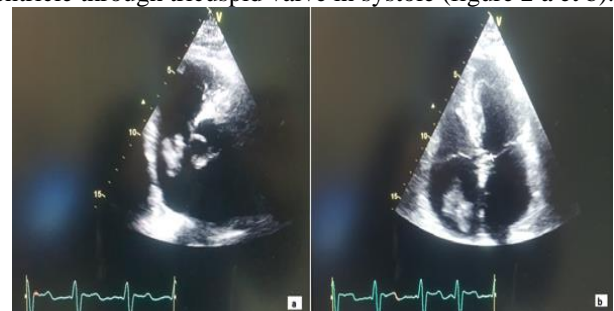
Transthoracic echocardiography: floating right atrial thrombus protruding towards the Right ventricle in systole
